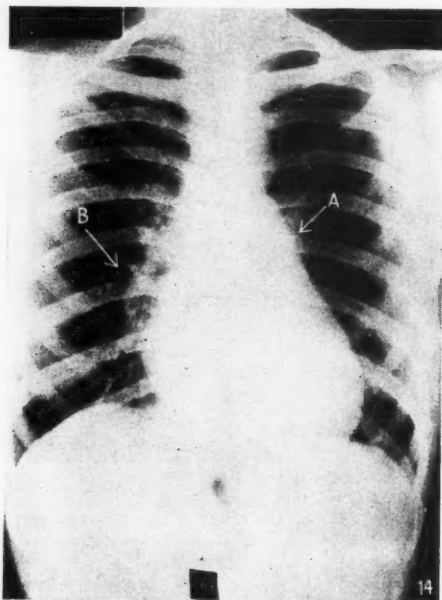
Note the filling of the pulmonary waist and the apparent prominence of the right border of the heart. This patient had a late systolic murmur and had been diagnosed mitral stenosis but all the changes in this X-ray are due to compression of the heart.
